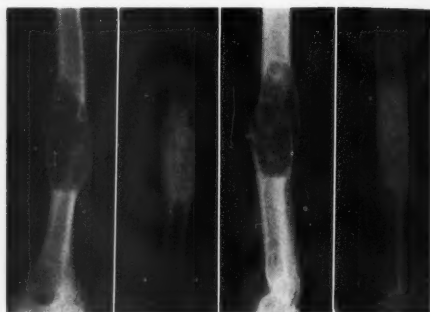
Case 15: Giant-cell tumor with pathologic fracture of mid-shaft of left humerus before and ten years after roentgen therapy. No biopsy.
